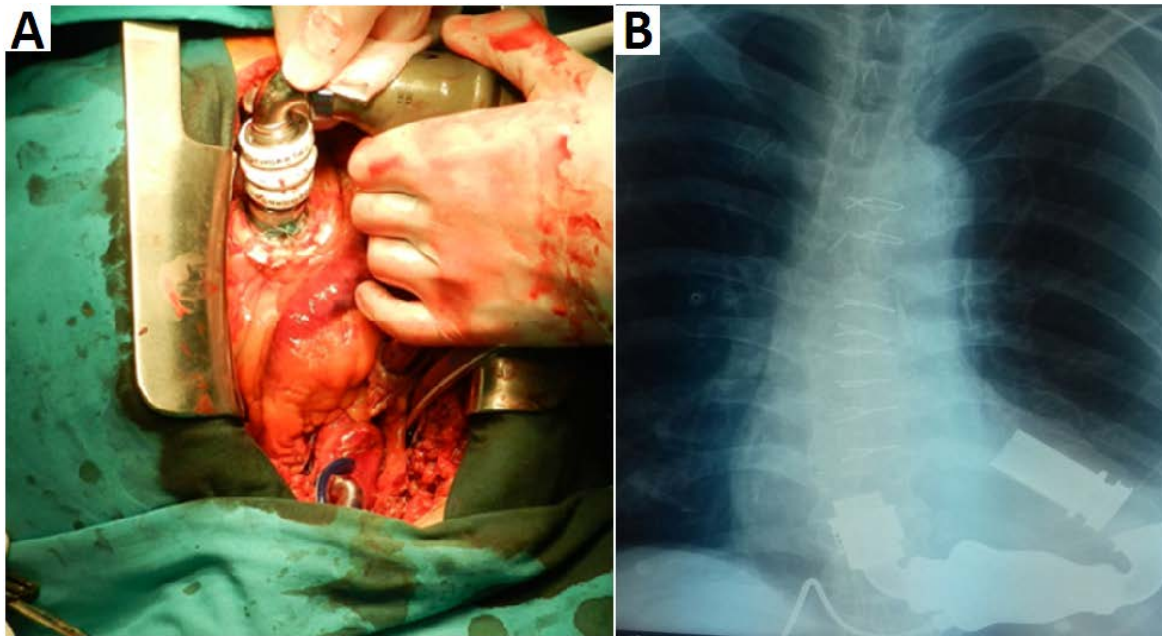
A) Left ventricular assist device (LVAD) Heart Mate II implantation as bridge to the heart transplantation; B) Chest X-ray after LVAD Heart Mate II implantation.
